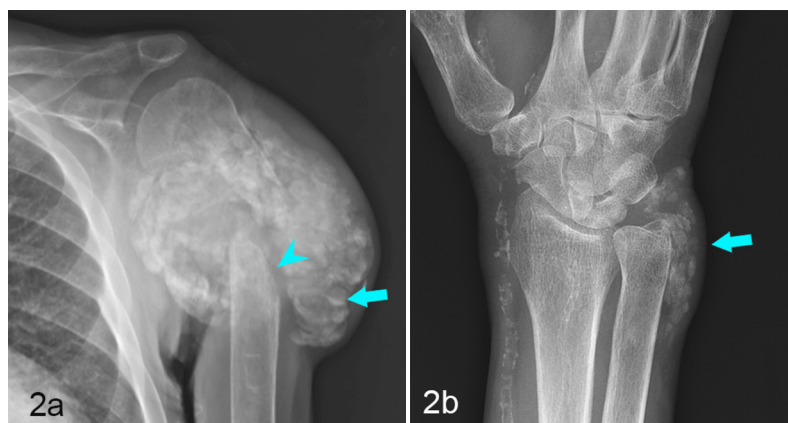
Four years following the initial injury, the patient presented to his primary care clinician with complaints of a firm left shoulder mass. (A) AP radiograph shows large amorphous calcification surrounding the fracture nonunion of the left proximal humerus. Notice the layering fluid level (arrow). The worrisome finding was the appearance of permeative destruction of the proximal humeral diaphysis (arrowhead). (B) AP wrist radiograph reveals amorphous calcification along the distal ulna (arrow) and extensive vascular calcifications.
